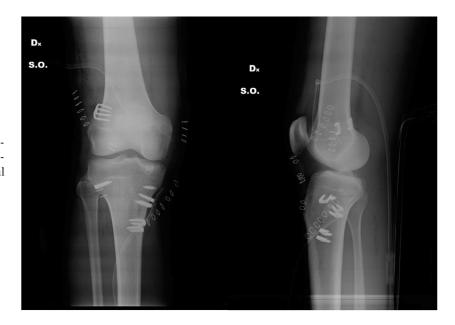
Final radiographic control demonstrates correct femoral and tibial staples positioning and absence of accessory tibial tunnels.
